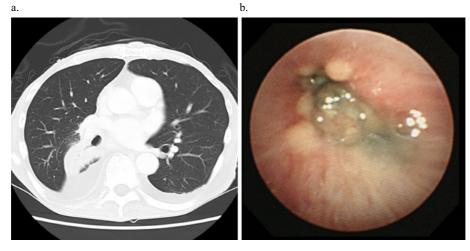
A chest computed tomography scan and bronchoscopic findings. a: Atelectasis of the right lower lobe. b: A tumor-like legion occluded the right lower bronchus.
